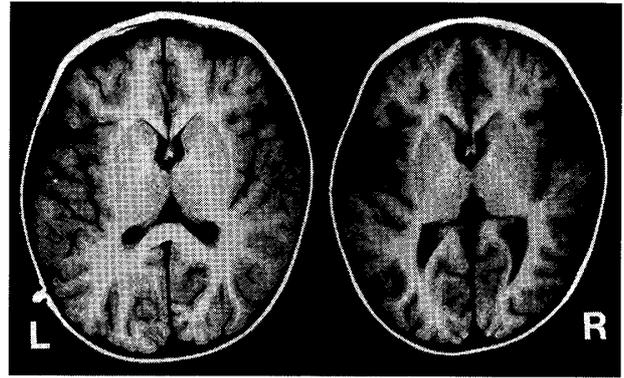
MRI revealed generalized brain edema on the 19th day (left) and moderate frontal and temporal diffuse brain atrophy on the 52nd day (right).
